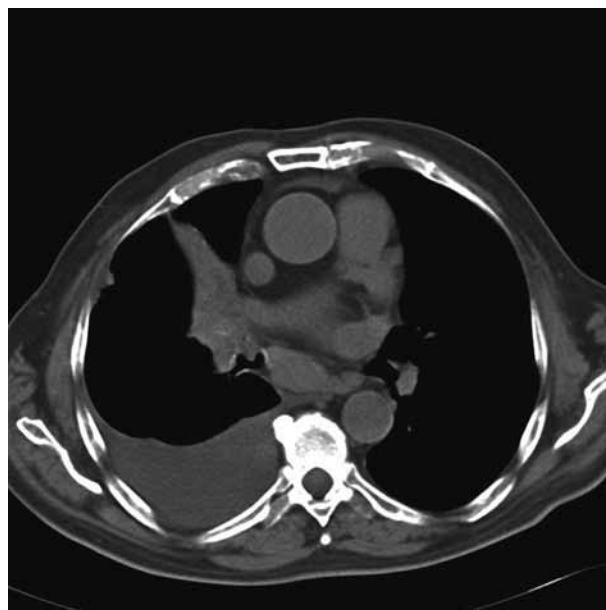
CT-scan showing an exofytic endobronchial tumoral mass, a retroobstructive parenchymal consolidation and a right-sided pleural effusion.
